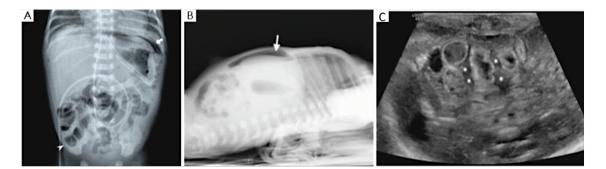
¹³ Absolute indication for surgery. A. Supine abdominal film: Free air (arrow) and intestinal pneumatosis (arrow head), B. Lateral decubitus abdominal film: Free air (arrow), C. Ultrasonography: Intraperitoneal free fluid: inhomogeneous free fluid between bowel loops with internal echoes and septa (*). In some intestinal loops hyperechoic spots within the wall are present.
